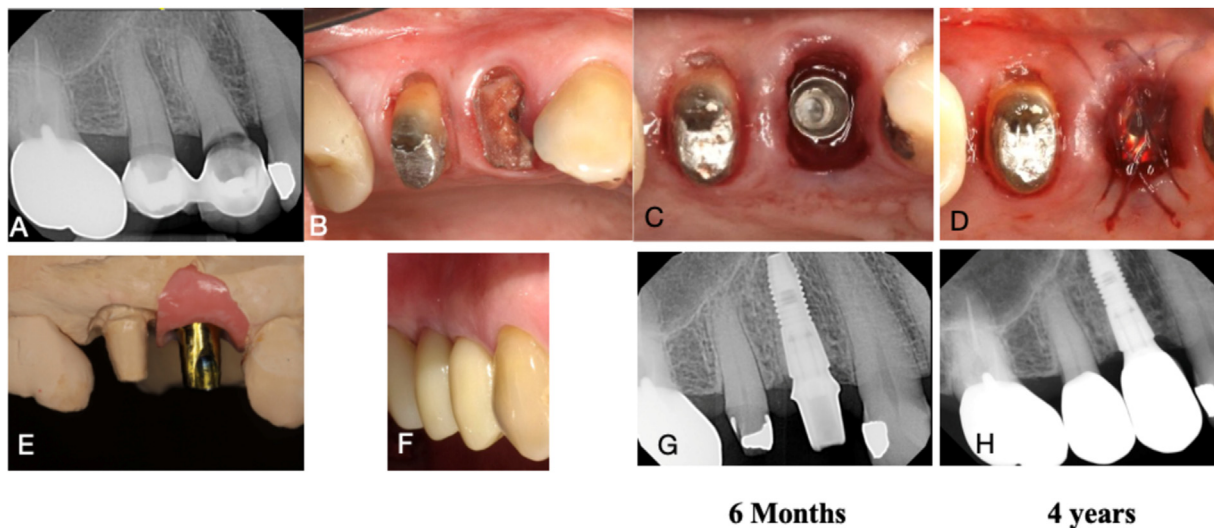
Tooth 14. A. Periapical radiograph before treatment. B. Fracture of tooth 14. C. Implant placement at the center of the socket of tooth 14 with primary stability. D. Bone graft, healing abutment applied and suture without soft tissue graft. E. Tooth 14 custom abutment mimics natural tooth 15. F. Final crowns with identical emergence profile between tooth 14 and tooth 15 (tooth 14 implant crown and tooth 15 natural tooth crown). G. periapical radiograph shows identical abutment design of tooth 14 and tooth 15 with the follow-up of 4 years. H. Final crowns show identical emergence profile of tooth 14 and tooth 15 with the follow-up of 4 years.
